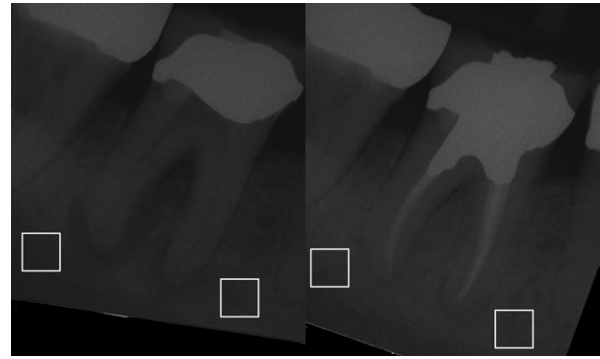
Periapical radiographs showing the regions of interest (white squares). Left image is before RCT and the right image after RCT.
